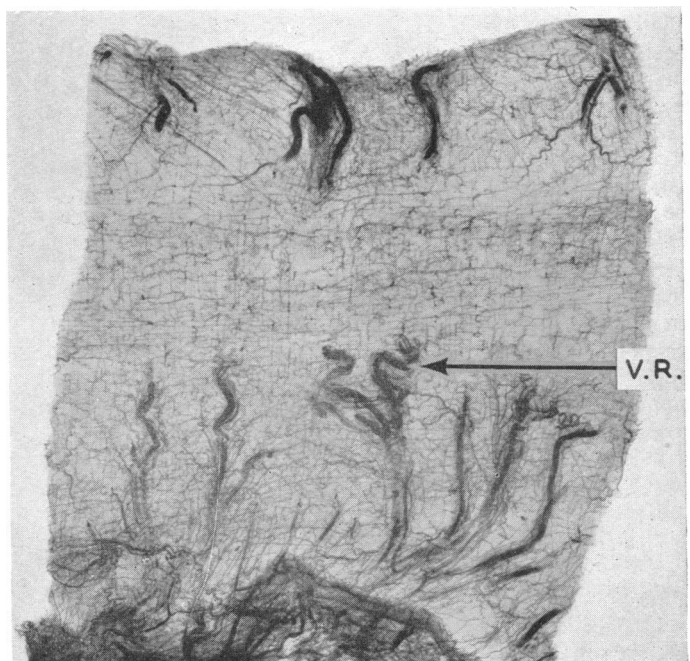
Radiograph of the muscle wall of the colon, the mucosa having been dissected free. Note the fine intramuscular plexus only supplied by small arteries from the submucosal plexus, and the point at which the vasa recti (V.R.) pierce the muscle coat.
